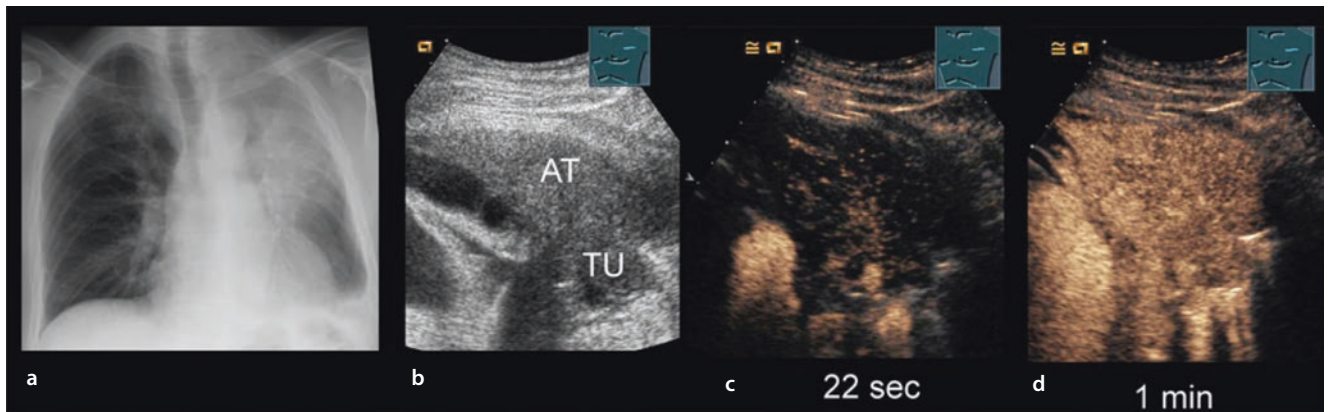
Man with bronchial carcinoma, after chemoradiotherapy. a The chest X-ray reveals shadowing of the upper field in the left lung. b B-mode ultrasound shows a central space-occupying lesion (TU) with downstream atelectasis (AT). c On contrast-enhanced ultrasound, after
